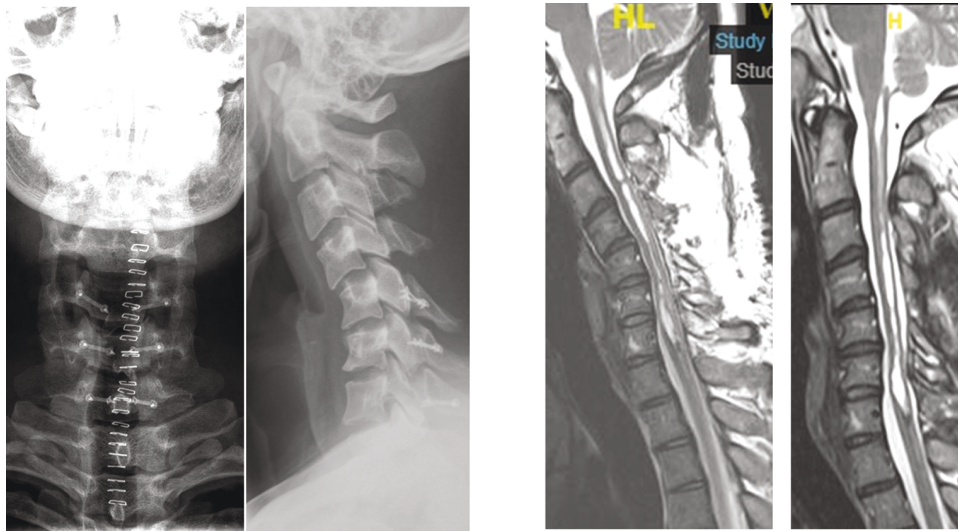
The same case as in [Figure 1](#) showing on plain x-ray the limited 3-level laminotomy in 2 planes and the immediate sagittal spine deformity which was present already in the preoperative situation. T2 images and is also seen somewhat accentuated postoperatively. After 1 year of follow-up, there is no indication in the sagittal T2 that the deformity which was suspicious of progressing toward a swan neck progressed but it rather showed that with adequate physiotherapy the region was stabilized and it also shows that the syrinx, - once the tumor is radically removed remains in its collapsed state.
